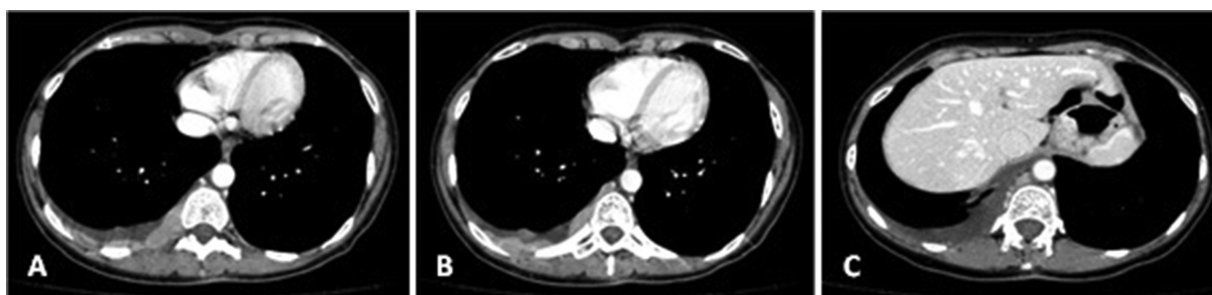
(A–C). Chest CT scan showing macronodular pleural thickening in lower half of right hemithorax with contrast hyperenhancement, associated to moderate right pleural effusion.
